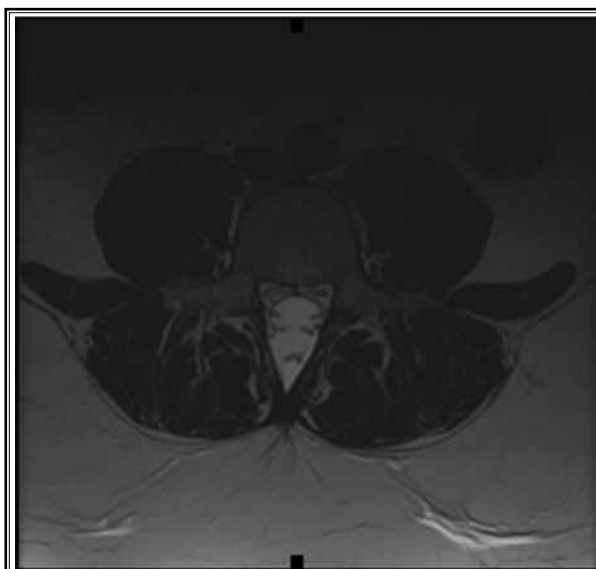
Axial T2 weighted MRI at the L4 level demonstrating tenting of the thecal sac.
